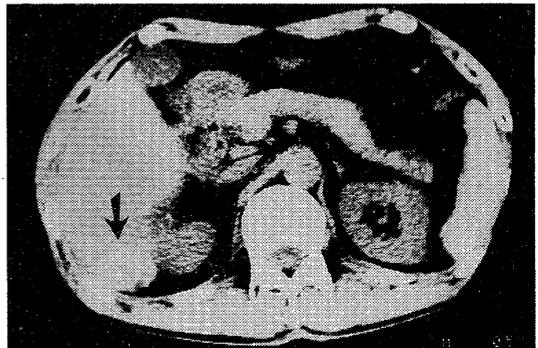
CT imaging 6 months after embolization in the same case as figure 3 showing a high density area with retention of lipiodol (arrow) and markedly reducing in tumor size.
